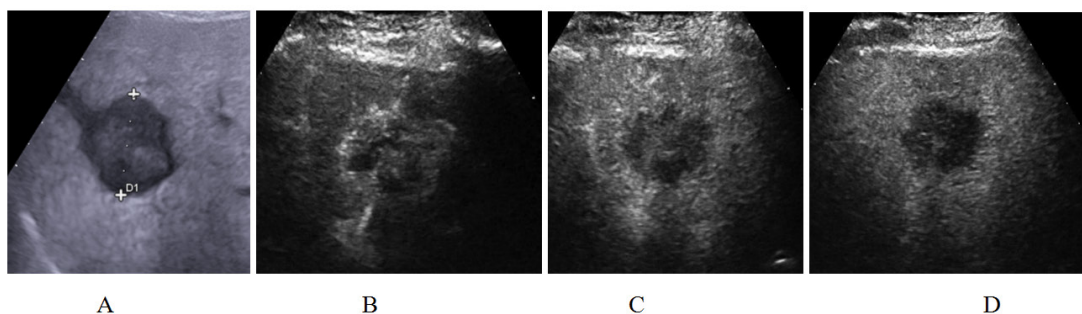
A) B-Mode ultrasound shows an unevenly hypoechoic nodule (caliper) and finely drafted irregular margins; B) During arterial phase, CE time started at 22 s and it is inhomogeneous; C) During portal phase (65 s): slight persistence of peripheral enhancement with intralesional wash-out is observed; D) Late phase shows hypo enhancement of the nodule.
